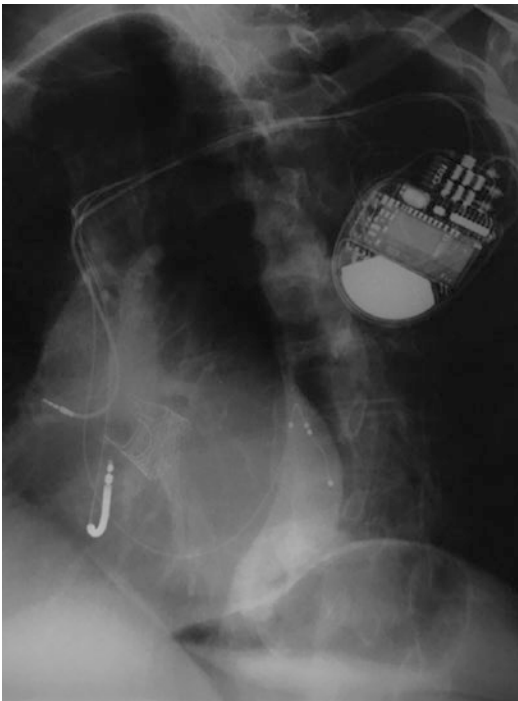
Successful implantation of a CRT-D device in a patient using a quadripolar LV lead. LAO Chest X-ray shows a good positioning of the lead on the lateral LV wall
